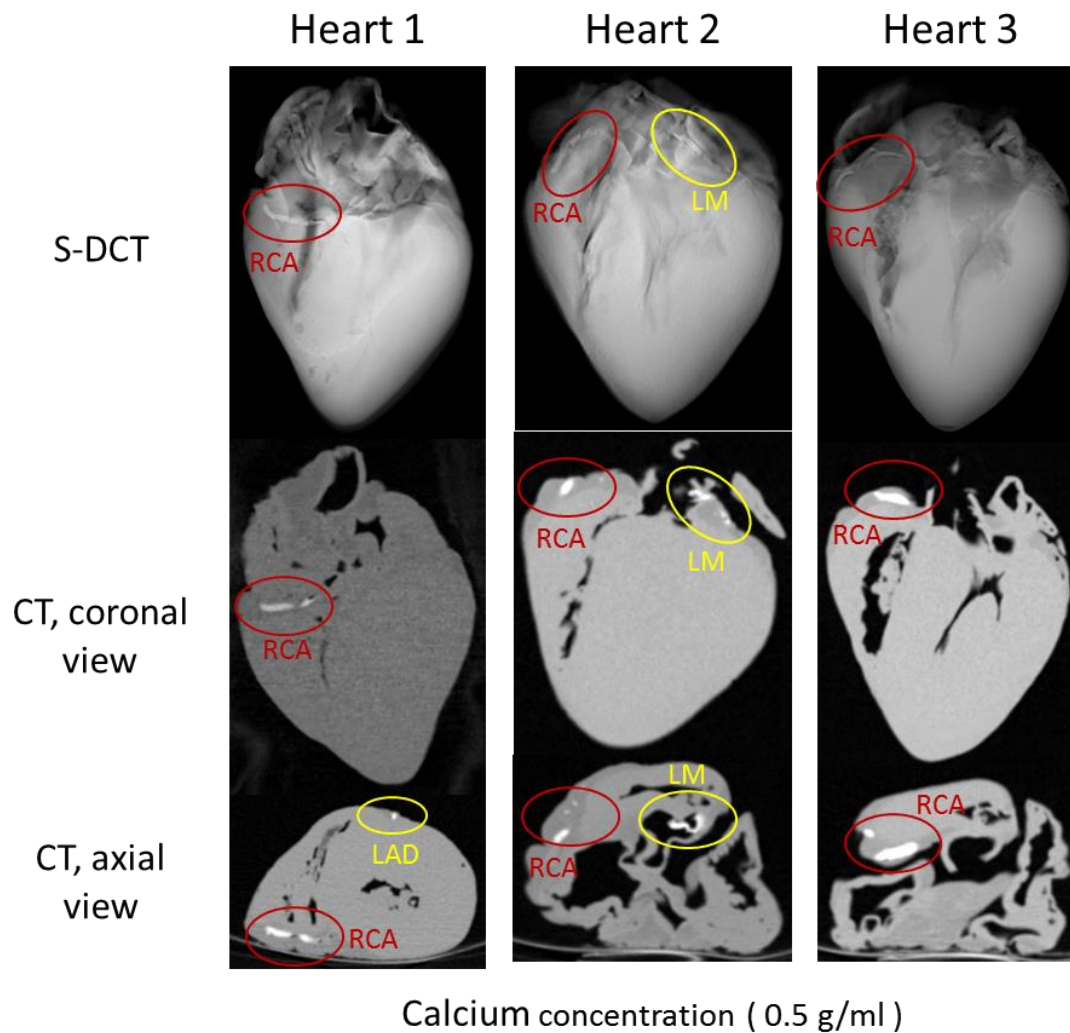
Mimic CAC in explant heart model imaged by both s-DCT and CT. Red and yellow circles mark the locations of the CAC.
